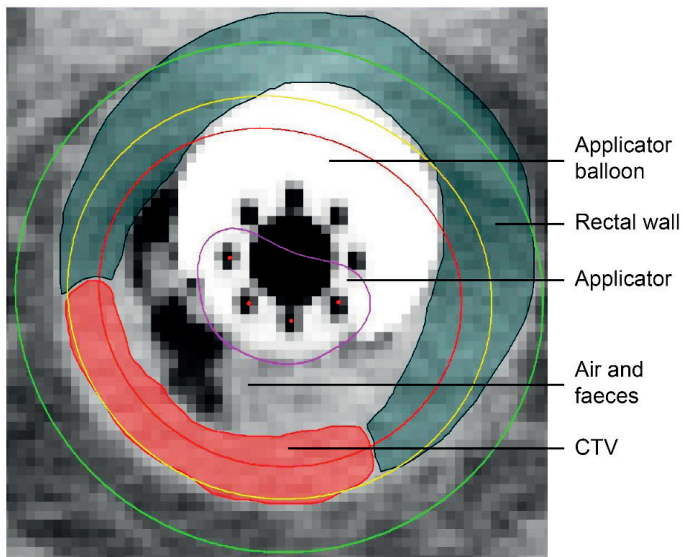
Example of a CT scan in which full coverage of the CTV was not possible considering the constraint of the 400% isodose within the applicator. Air and faeces are seen between the CTV and the applicator. The 400%, 100%, 75% and 50% isodoses are shown. CTV, clinical target volume.
